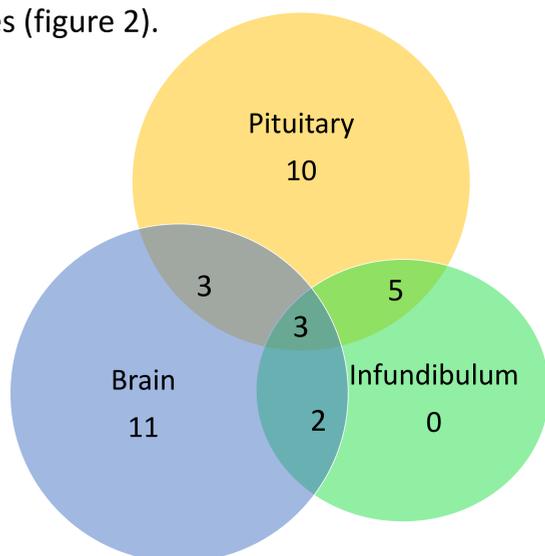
Types of MRI abnormality
